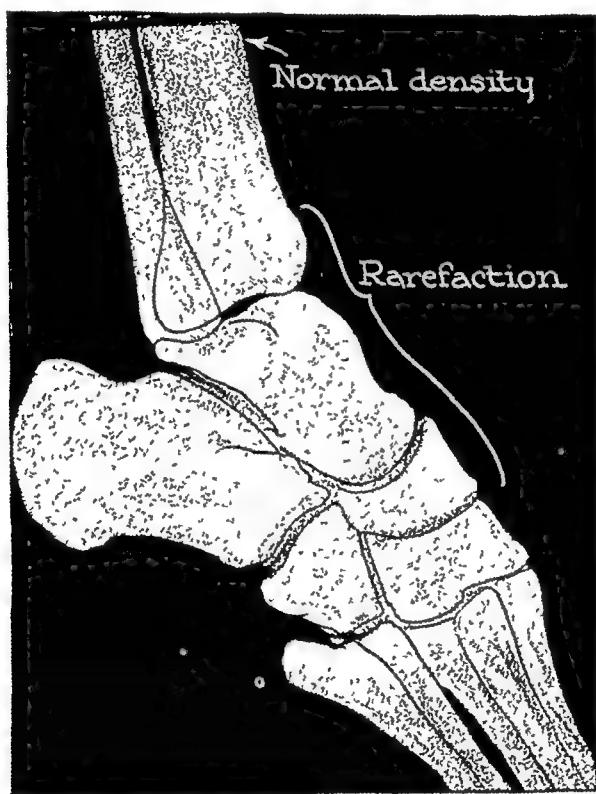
Osteoporosis of ankle bones and their contiguous bones due to pyogenic infection. (Redrawn from roentgenogram)
